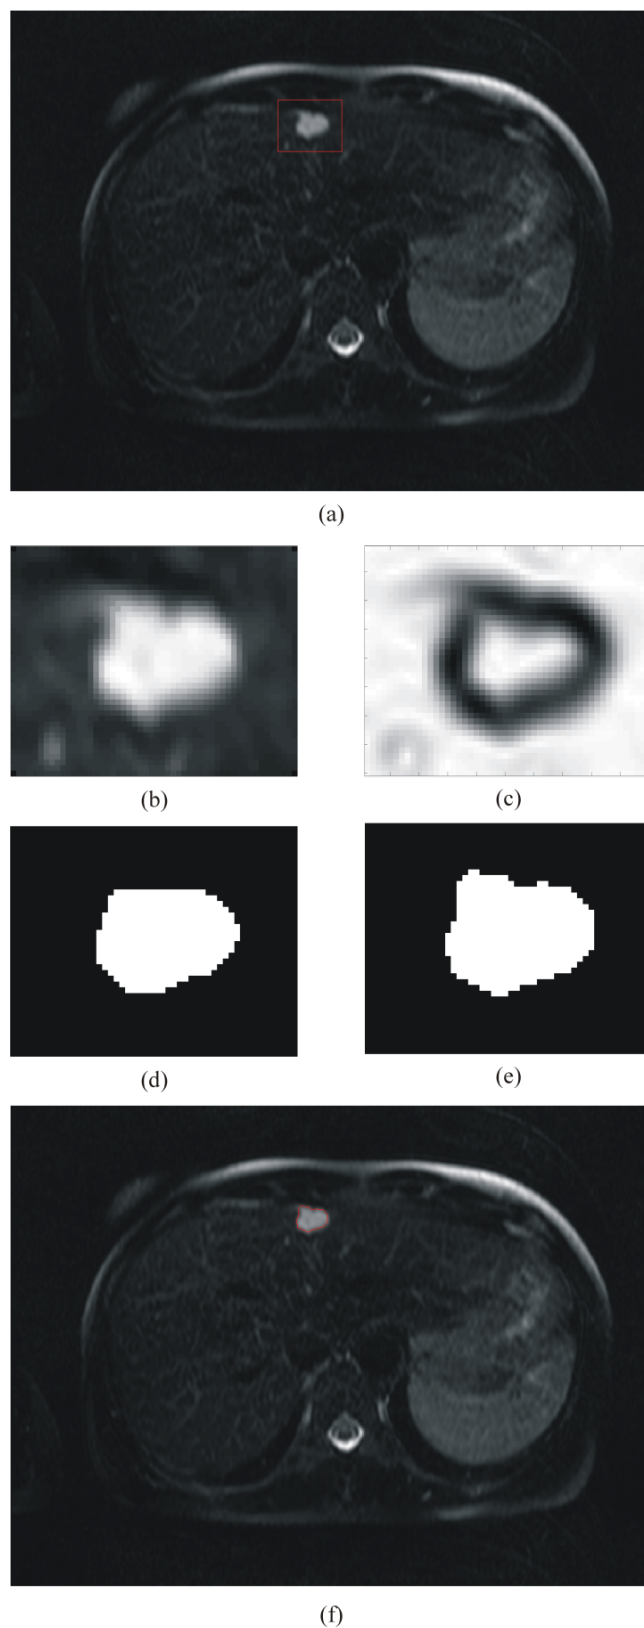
MRF segmentation with edge driven FCM initialization. (a) MR image with lesion selected, (b) Lesion cropped, (c) Edge Indicator Function, (d) FCM initialization, (e) MRF segmentation, (f) Lesion outlined.
